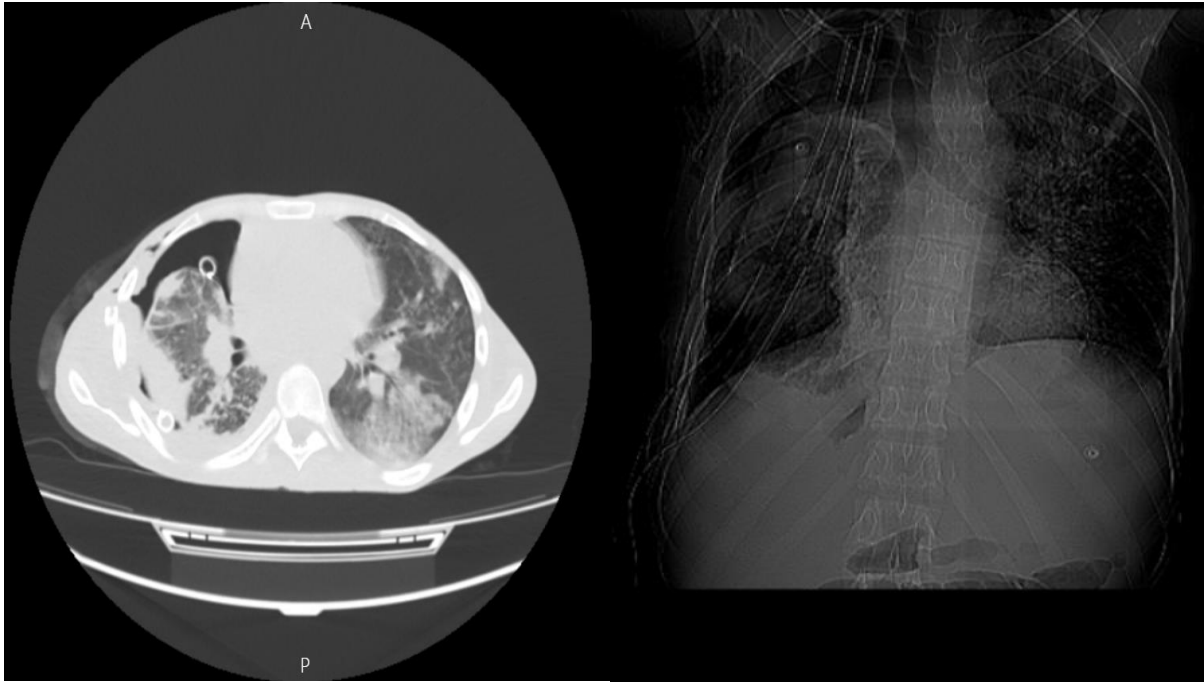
chest X-ray and CT after insertion of two chest tubes
